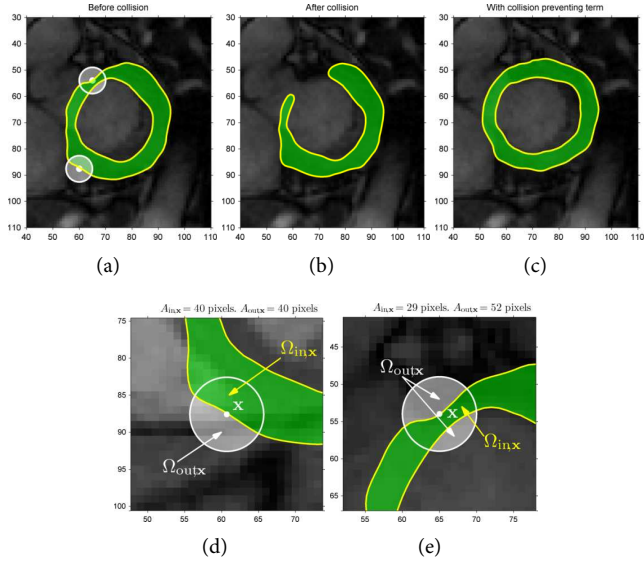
In (a) the two contours soon before the collision. Two regions, corresponding to a safe distant-contours situation and a warning close-contours situation are represented as white disks. In (b) the active contour after the collision. In (c) the result obtained thanks to the collision preventing term. In (d) and (e) a zoom of the two regions corresponding to distant and close contours respectively. The image is taken from a cardiac MRI exam.
